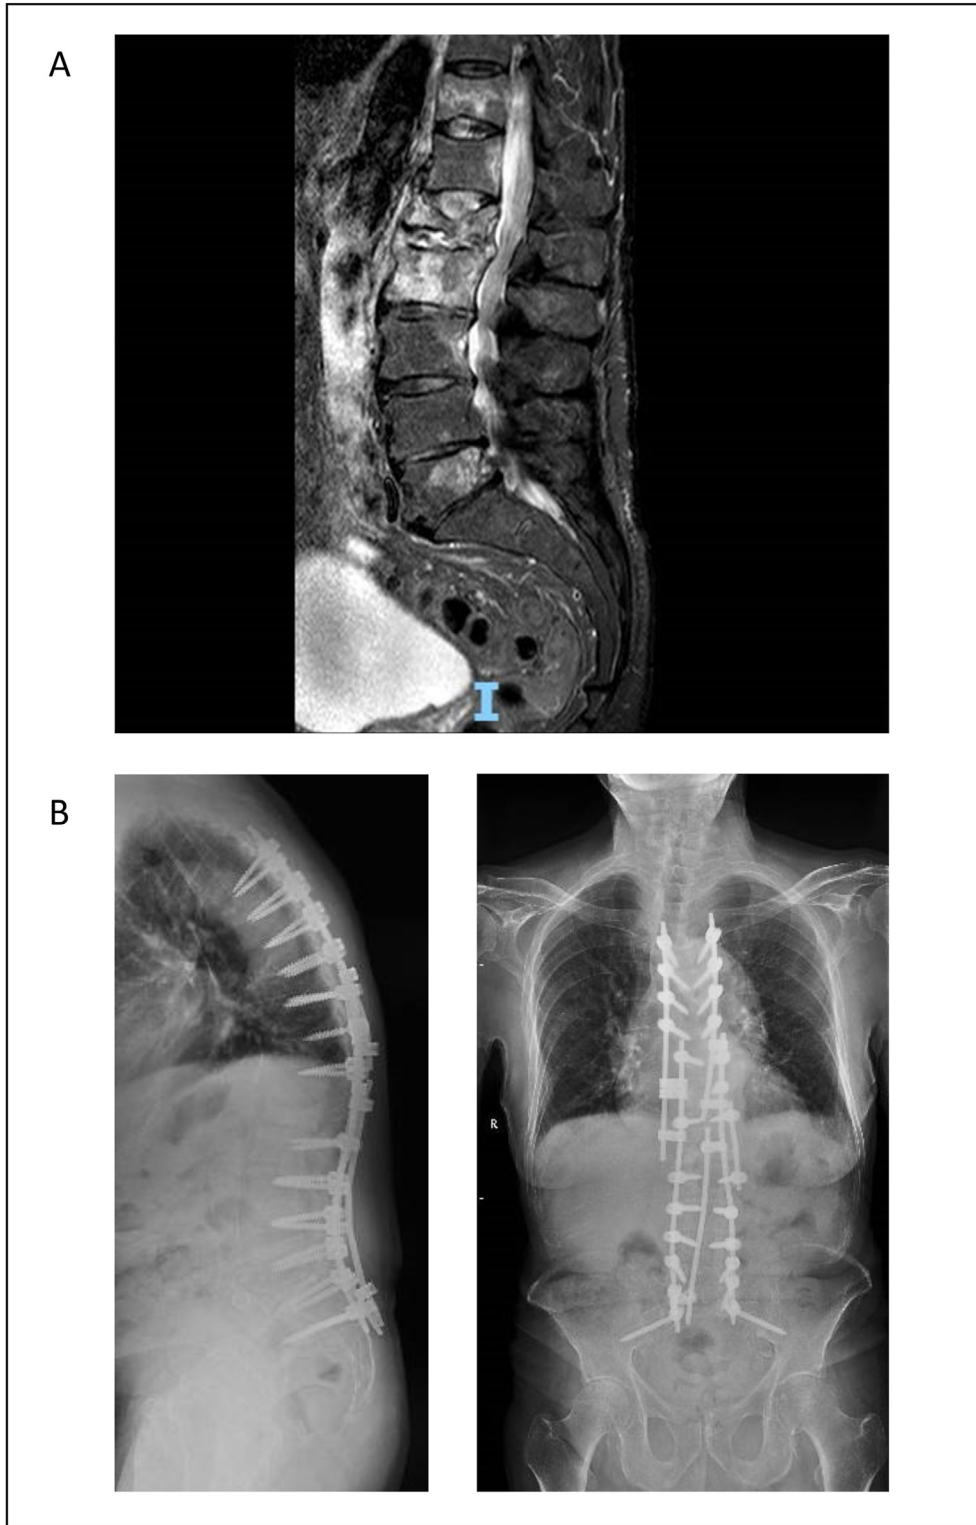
A) Magnetic resonance imaging of the spine showing high signal intensity in the L1-L2 vertebral body, compatible with lumbar osteomyelitis. B) Spine radiography after stabilization achieved by a posterior spinal segmental instrumentation, decompression and fusion, with bars and screws.
